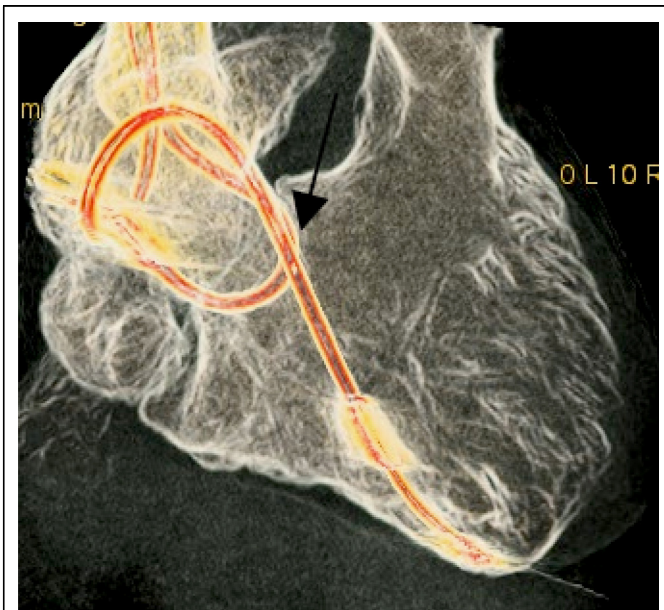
Contrast-enhanced cardiac computed tomography of the heart (volume rendered image) demonstrates the atrial pacemaker lead forming a loop as it crosses down to the right ventricle and returning to the right atrium against the septal leaflet.
